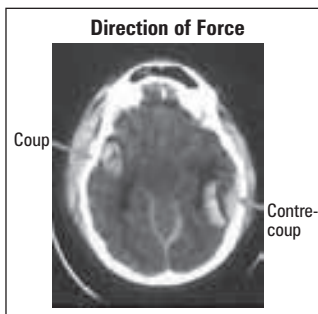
CT Showing Coup-Contre-Coup Injury
